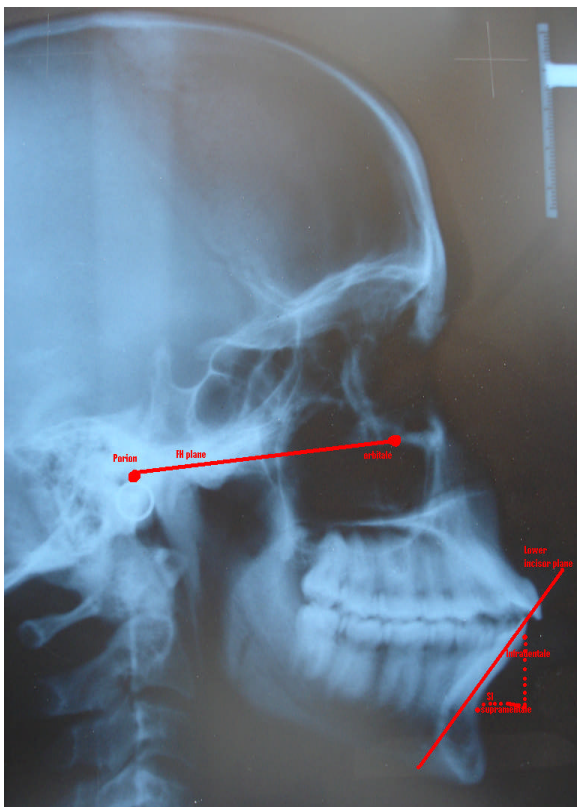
Cephalometric radiograph of dentulous patient
